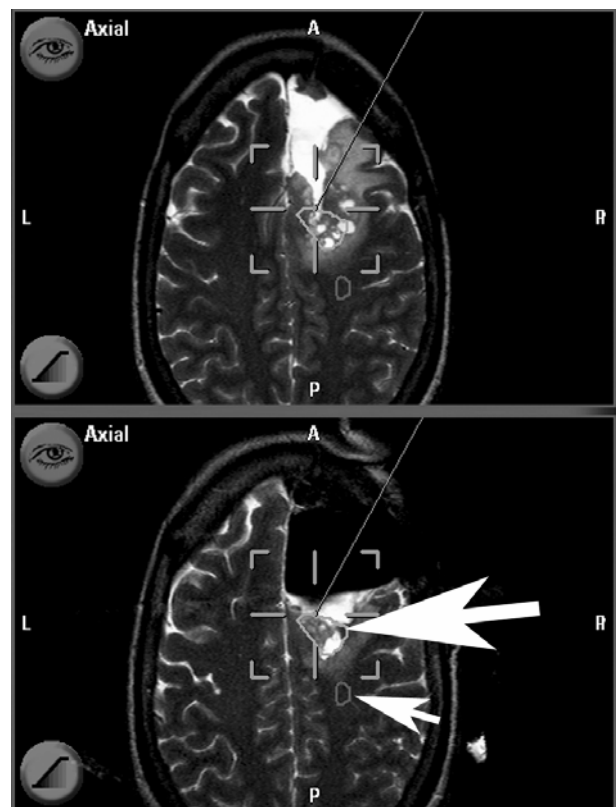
Recurrent right frontal astrocytoma WHO III in a 33 years-old female patient; co-registered T2-weighted axial images (upper: pre-, lower: intraoperative), the large white arrow depicts the segmented tumor remnant adjacent to the pyramidal tract (small arrow) identified by diffusion tensor imaging.
